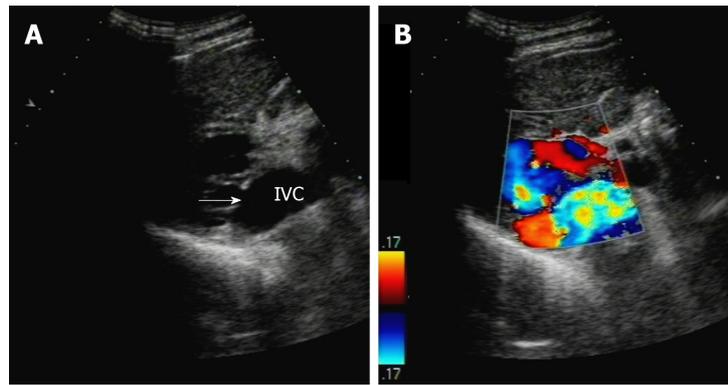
Ultrasonography revealed a spontaneous intrahepatic portosystemic shunt. A: The branch of the right portal vein connects to the inferior vena cava through (arrow); B: The extrahepatic venous plexus showed turbulent spectrum locally. IVC: inferior vena cava.
